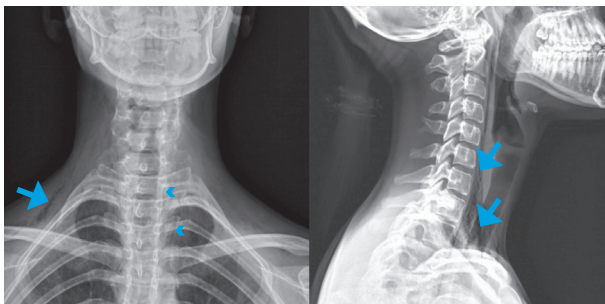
Neck and chest radiographs reveal subcutaneous emphysema (arrows) and gas crossing the superior mediastinum (arrowheads).
